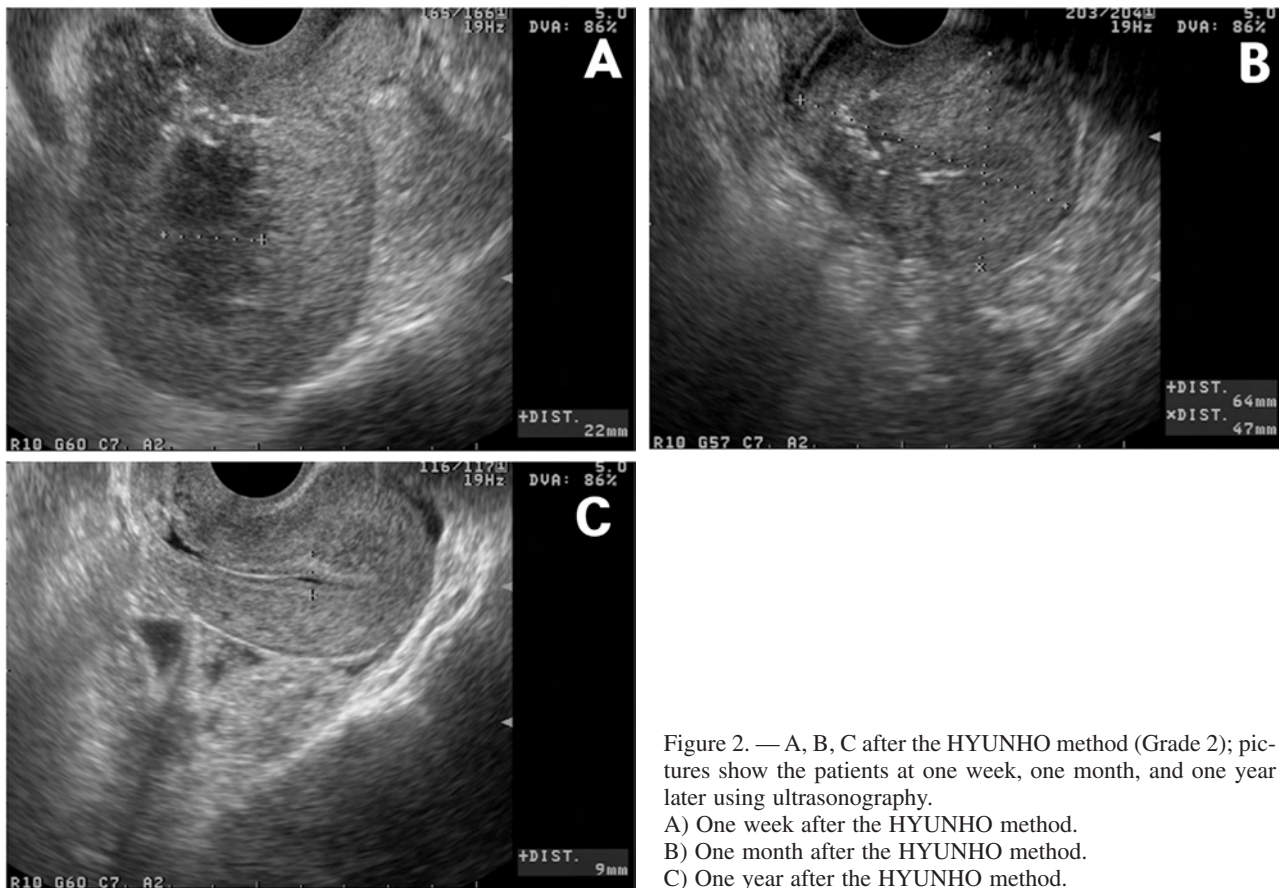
A, B, C after the HYUNHO method (Grade 2); pictures show the patients at one week, one month, and one year later using ultrasonography.
